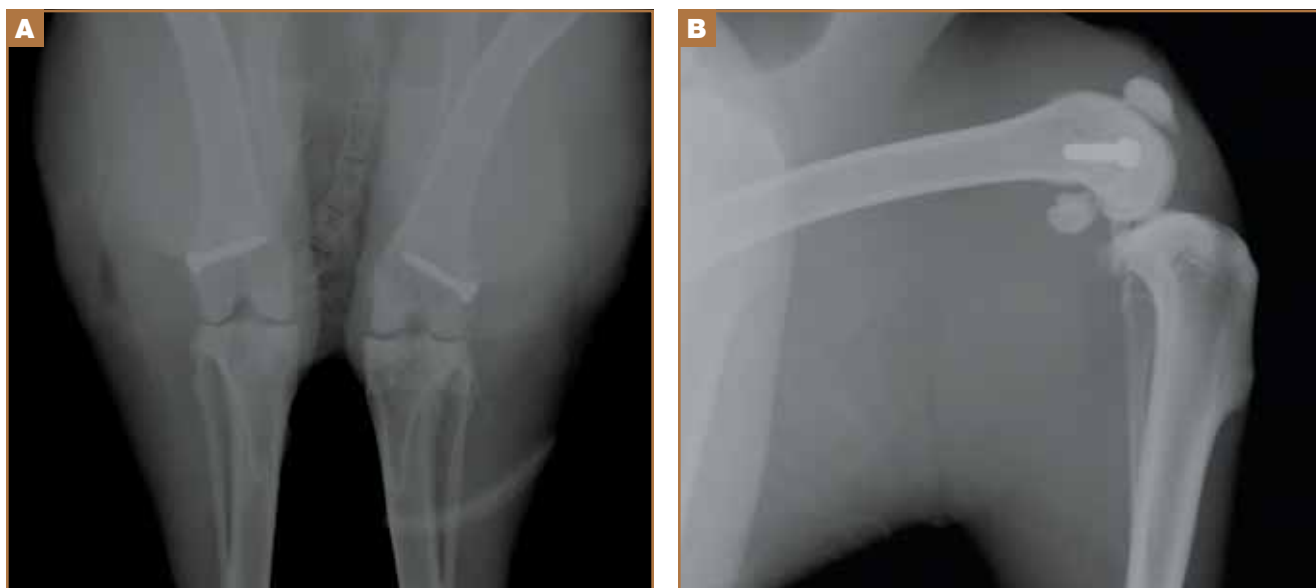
(A) Anteroposterior and (B) lateral radiographic views show bilateral screw implantation in an intra-articular yet non-weight-bearing aspect of the lateral femoral condyle.
